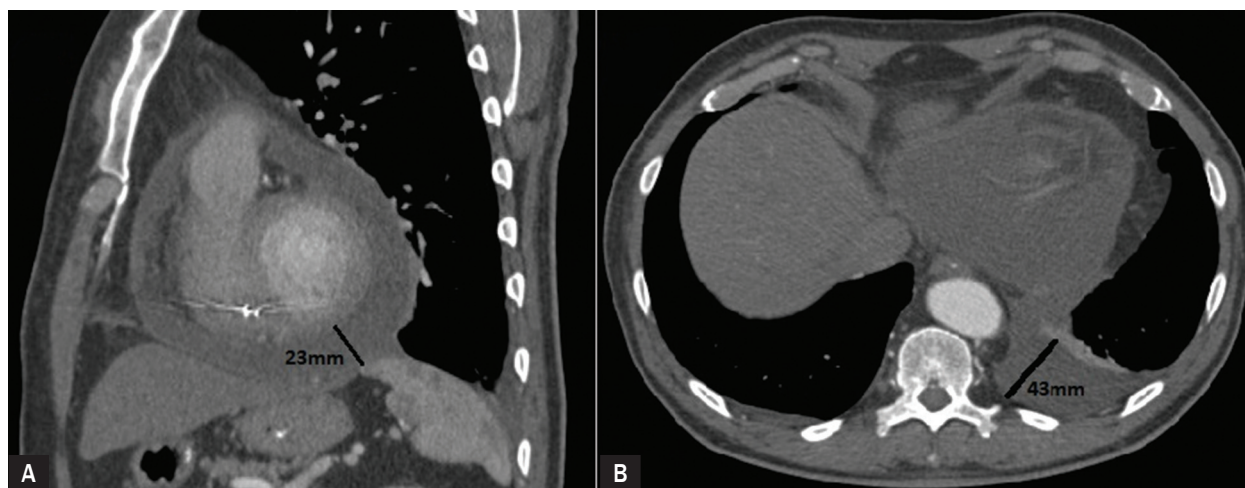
Chest computed tomography (CT): fluid in pericardium 23 mm; B. Chest CT: fluid in left pleura 43 mm
